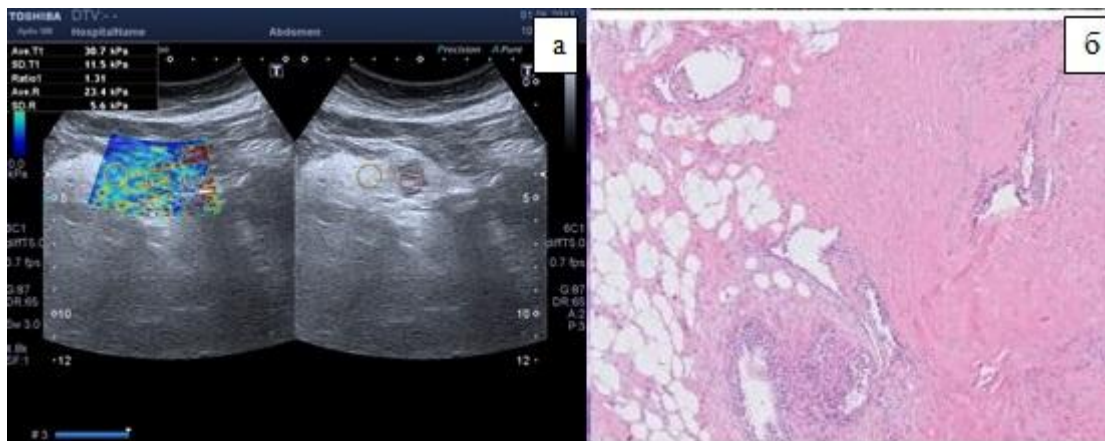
Serous cystadenoma of the pancreas. a — ultrasound scan, elastography. b — micropreparation (increase $\times 40$)
